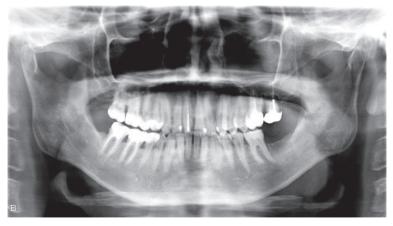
Panoramic radiograph image. Over-filling of root canal filling material was observed together with a radiolucent area at the root apex of the upper left secondary molar.
